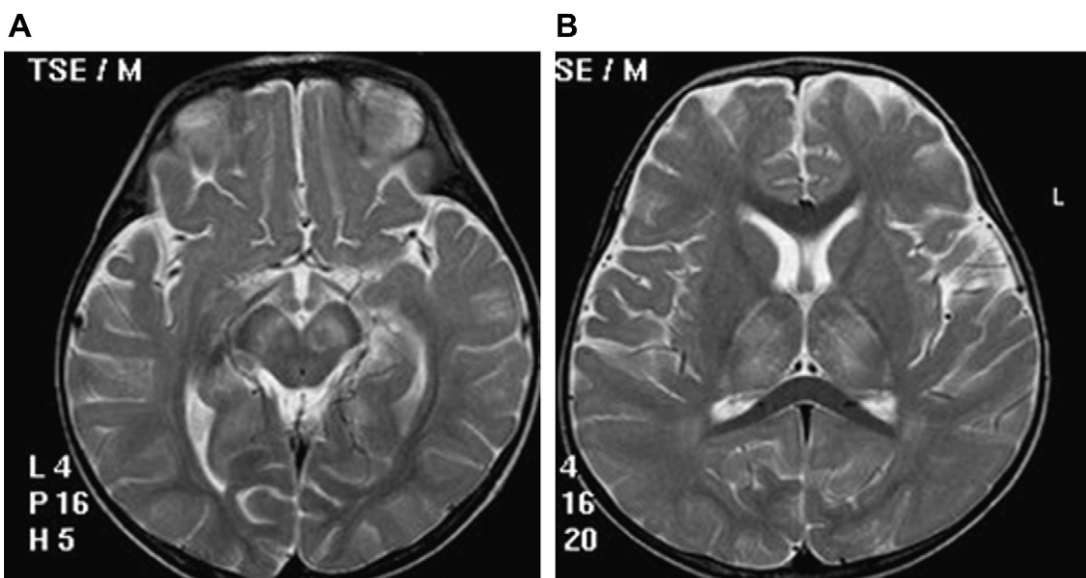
Japanese encephalitis. (A, B) T2-weighted image demonstrates abnormal signal involving the midbrain (A) and bilateral thalami (B). (Courtesy of Hemant Parmar, MD, University of Michigan.)
